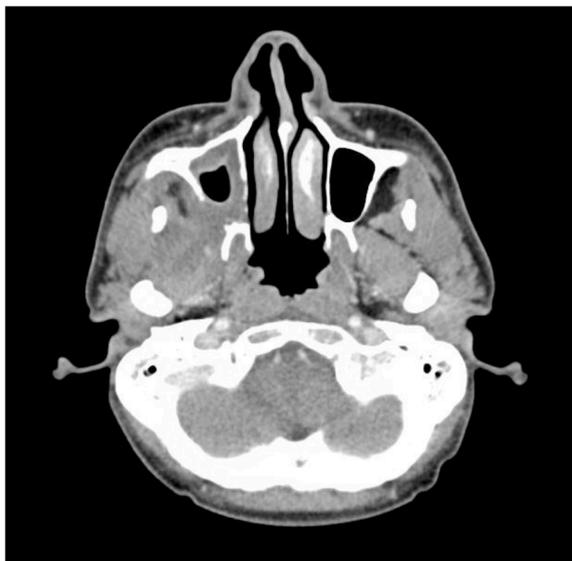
A 1-week post-treatment CT neck with contrast soft tissue window, axial cut, showed interval decrease in size of soft tissue mass in left maxillary sinus and masticator space.
